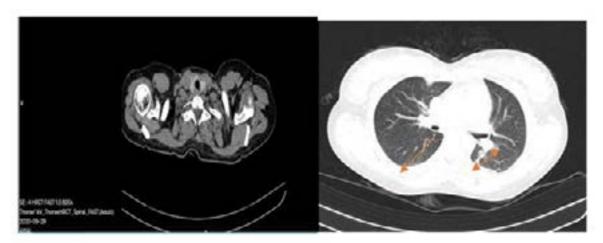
HRCT Thorax reveals sub segmental atelectasis right side and consolidation on left side with moderate bilateral pleural effusion in view of COVID positive PCR test imaging grading is CORAD 6 and CT severity score-4/25
